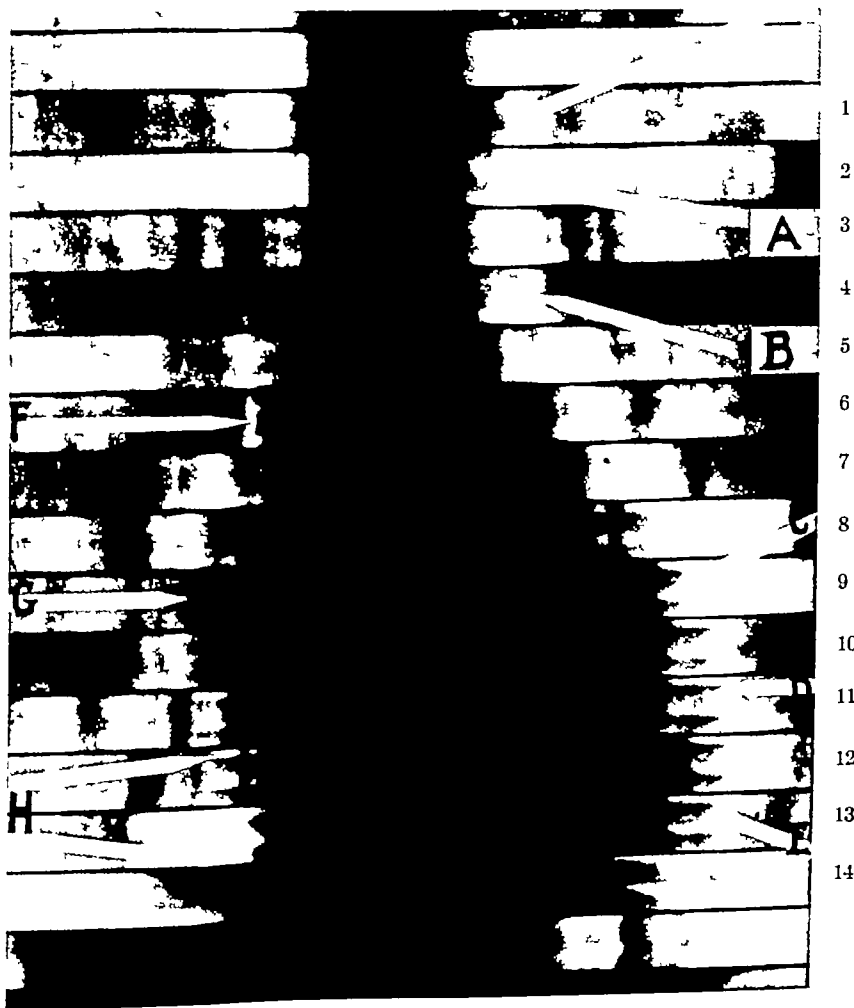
Roentgen kymogram of normal heart (a) Peak of aortic wave attained just after onset of ventricular systole (b) Waves produced by pulmonary artery, (c) Maximum systole at trough of wave (d) Maximum diastole at peak of wave, (e) Notch produced by systole of auricle (f) Wave produced by auricular appendage, (g) Trough of auricular wave corresponds to peak of ventricular wave, (h) Right lower cardiac border is formed by the right ventricle
